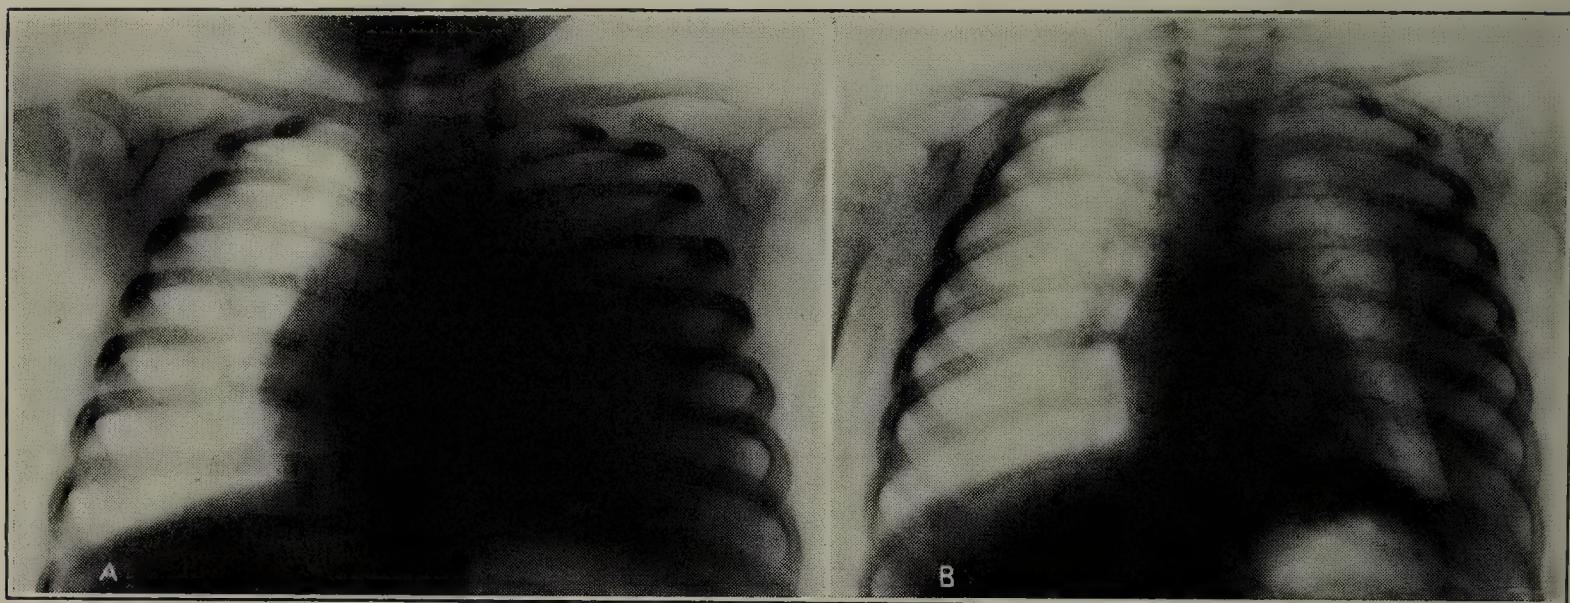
ROENTGENOGRAMS IN EMPYEMA.
